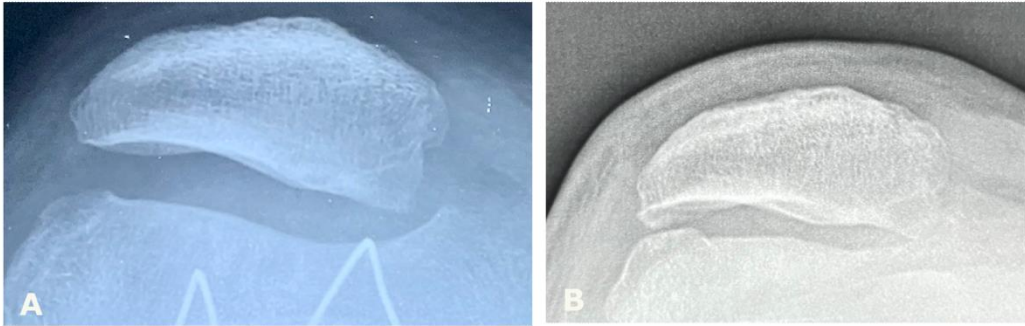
Incongruent patellofemoral joint example. (A) Immediate postoperative axial view x-ray of a trochleoplasty patient. (B) 17 years of follow-up axial view x-ray after fixation devices removal.
